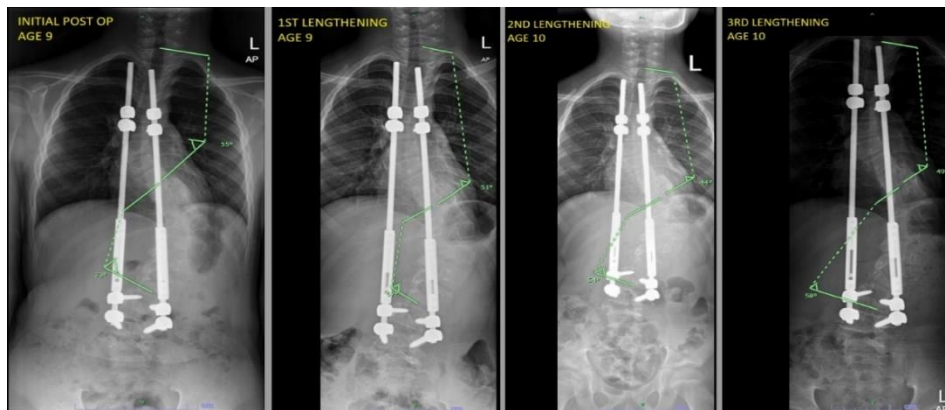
Whole spine AP radiographs during traditional growth rods lengthening
